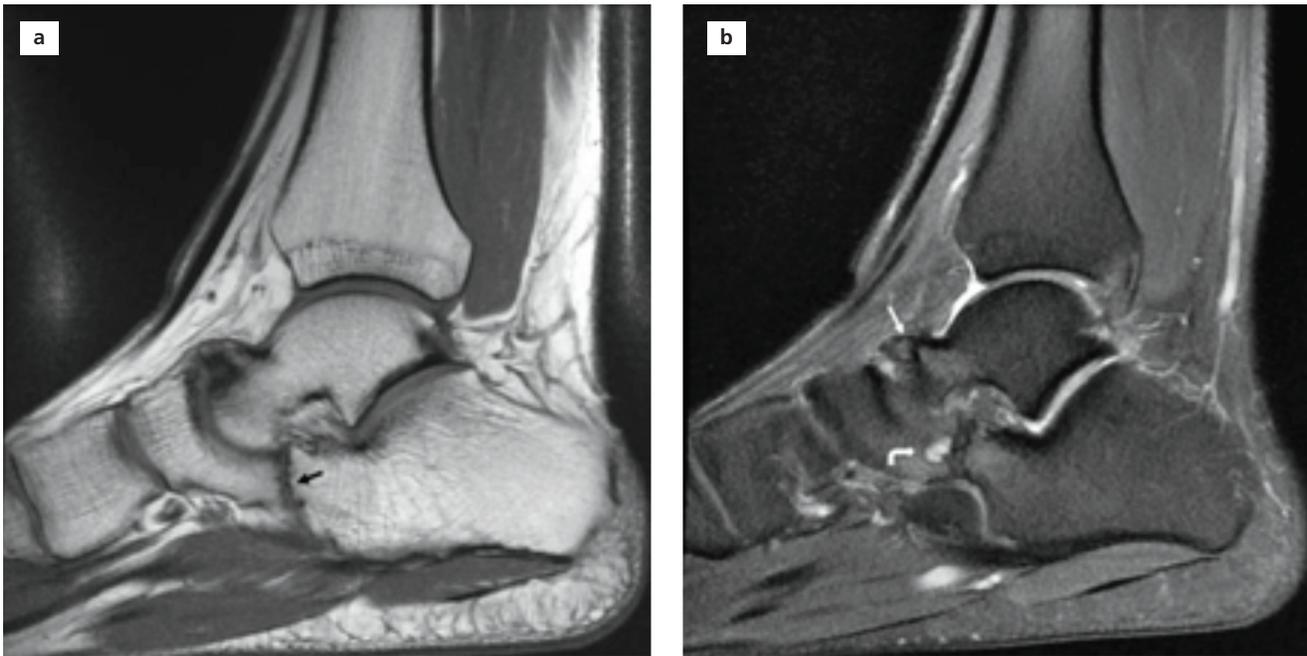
(a) Sagittal T1-weighted and (b) T2-weighted fat-suppressed images demonstrate the narrowing of the joint and irregularity of the bone margins in the calcaneonavicular joint. The sagittal T1-weighted image also shows the talar beak (white arrow) and accompanying medullary edema or cyst (curved white arrow).
